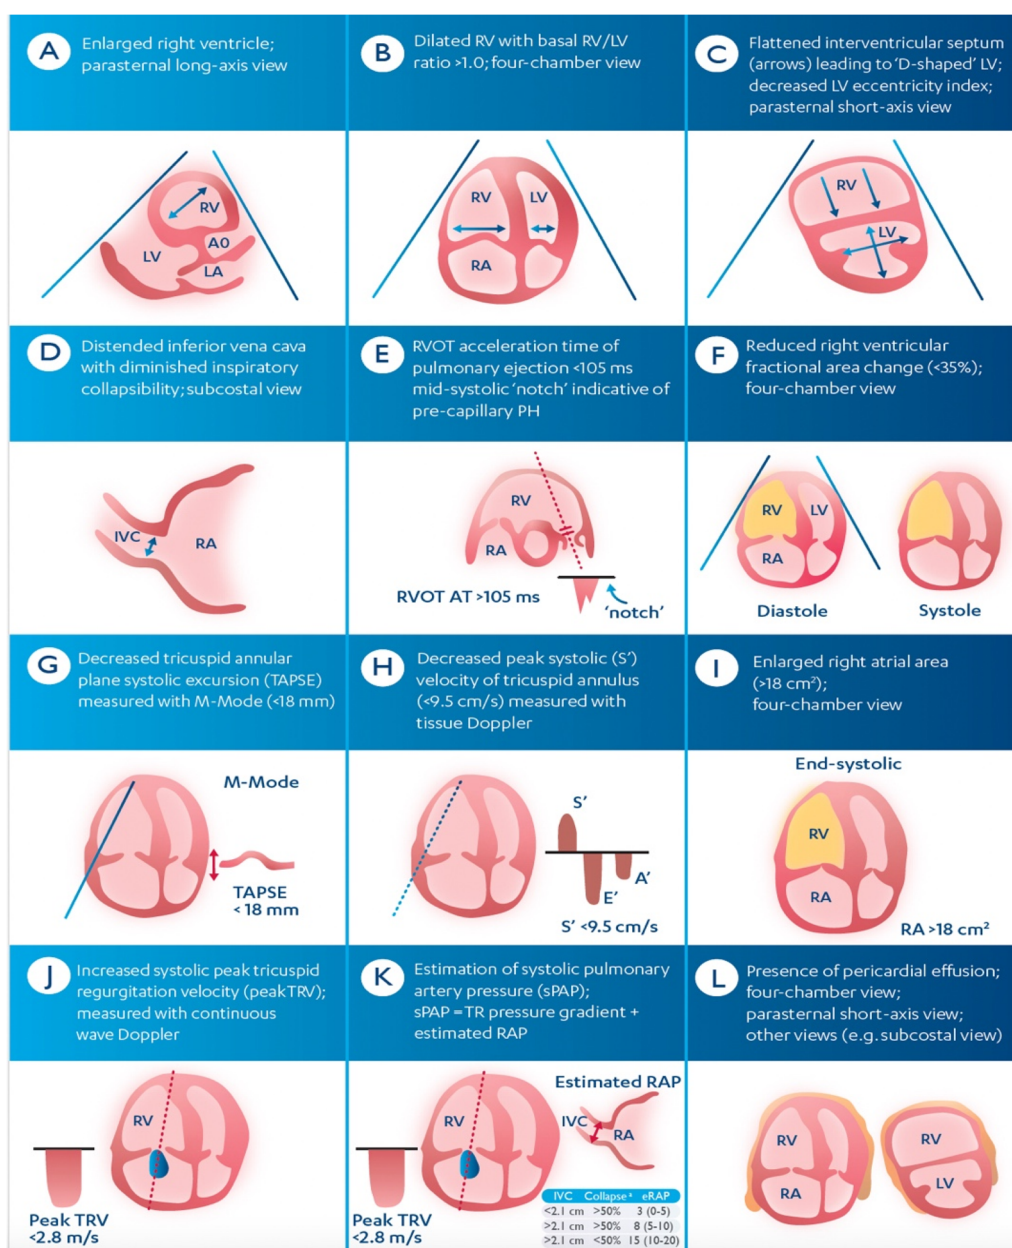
Echocardiography pictogram of parameters for pulmonary hypertension (from reference [4]).
